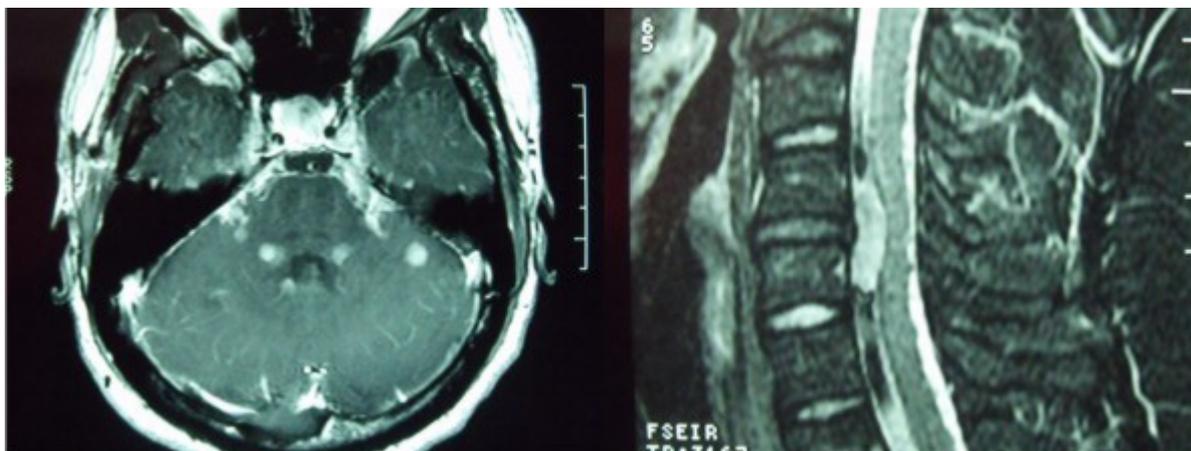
MRI images demonstrating multifocal lesions in suprasellar cistern, cerebellopontine angle, involving the brainstem, and an extramedullary intradural lesion in cervical level C5/C6.
